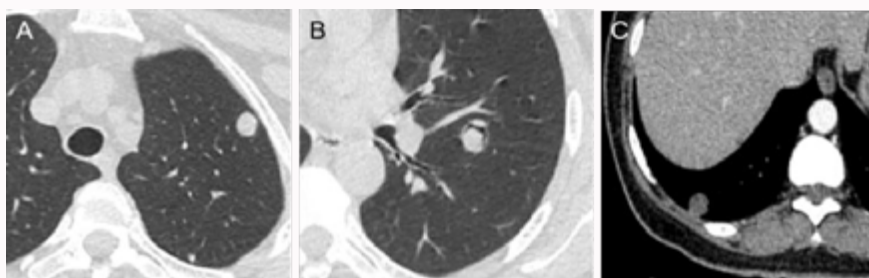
Coronal and sagittal CT images of the chest depict multiple well-defined bilateral pulmonary nodules in predominately peripheral locations. A) The larger nodules were in the lateral basal segment of the right lower lobe. B) The left lung mass with an "air crescent sign" can be seen running through the largest mass in the lateral basal segment of the right lower lobe. C) Contrast-enhanced CT scan in the arterial phase shows the right lower lobe nodule with marginal enhancement in the mediastinal window.
